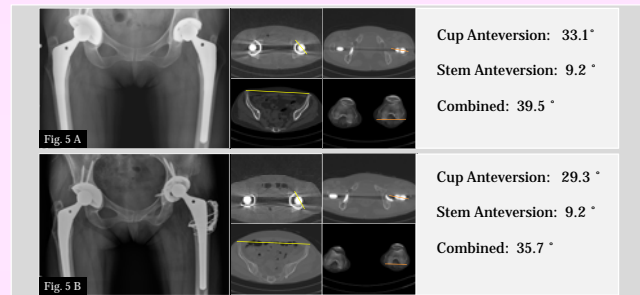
53-year-old female patient with osteolysis; Revision of the cup only Preoperative (A) and Postoperative (B) X-ray and CT
